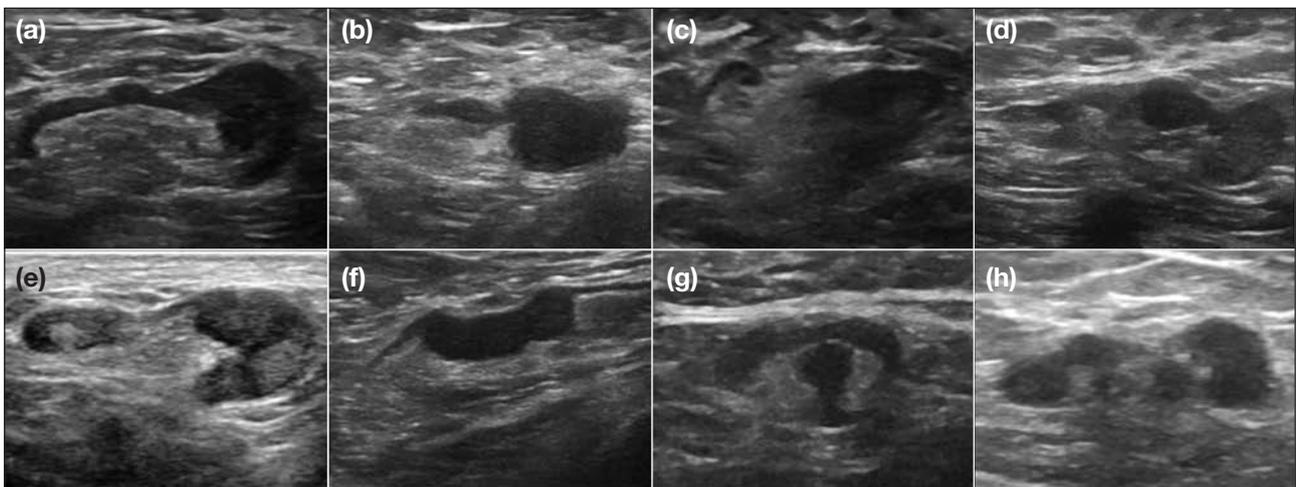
Ultrasound images of selected lymph nodes in the high suspicion group (Group 3), which were those with focal cortical thickening (≥ 3 mm), as evidenced by focal lobulation or bulging of the cortical outer contour (Figure 6a to d), which did not follow the contour of the central hilum. There might be focal indentation (Figure 6e and f) or erosion (Figure 6g and h) into the echogenic central hilum. No severe hilar compression or displacement was evident.
